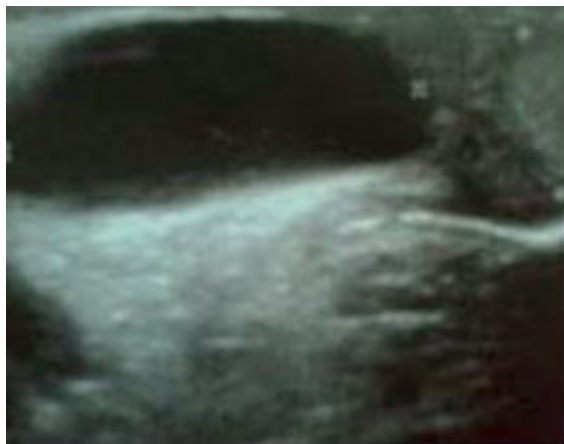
Ultrasound imaging of the 2 cm diameter intraparenchymal epididymal cyst (3rd case).
